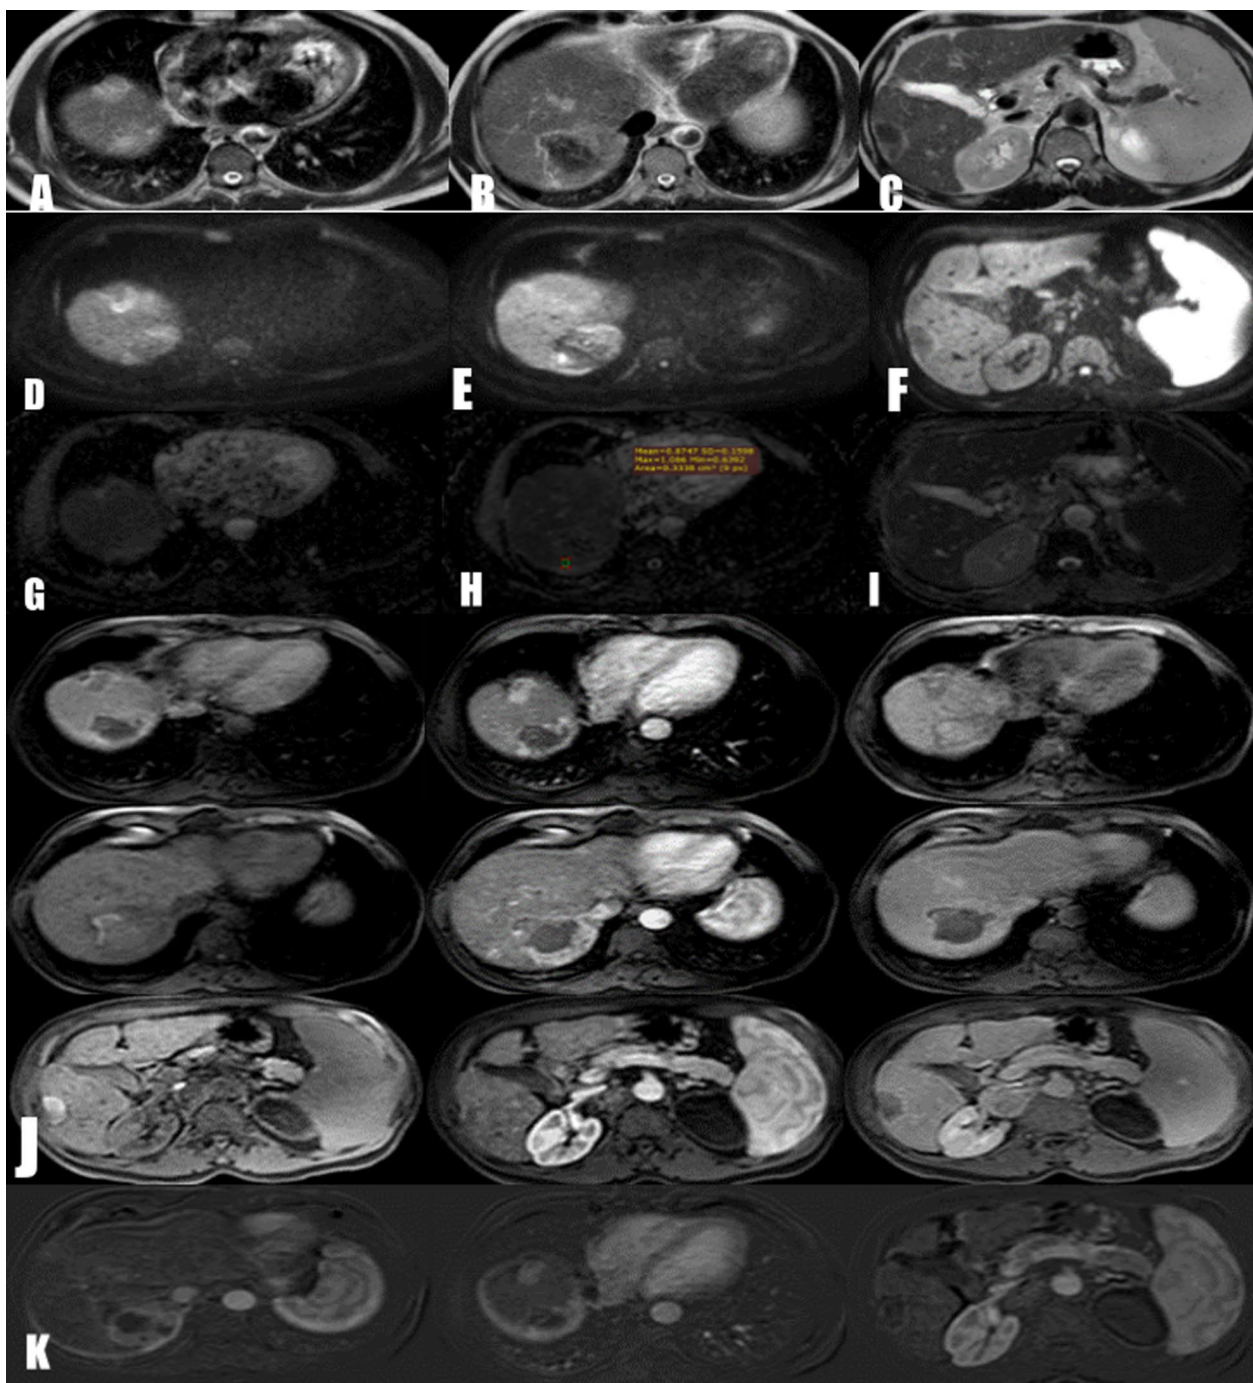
MR imaging of male patient 2 m after combined microwave and TACE for multifocal right lobe HCC. A–C Axial T2 seq. reveals coagulative necrosis within central portion of ablated lesion and peripheral hyperintensity at segments VIII and VII focal lesions. D–I Diffusion MR study and ADC map reveals areas of restricted diffusion at periphery of segments VIII and VII (ADC value = 0.8) as well as free diffusion of segment V/VI focal lesion. J & K Dynamic contrast-enhanced MR study and subtraction reveal no contrast enhancement of segment V/VI focal lesion at arterial or portal phases as well as areas of arterial and portal enhancement at periphery of segments VIII and VII focal lesions with delayed washout denoting viable tumor tissue
